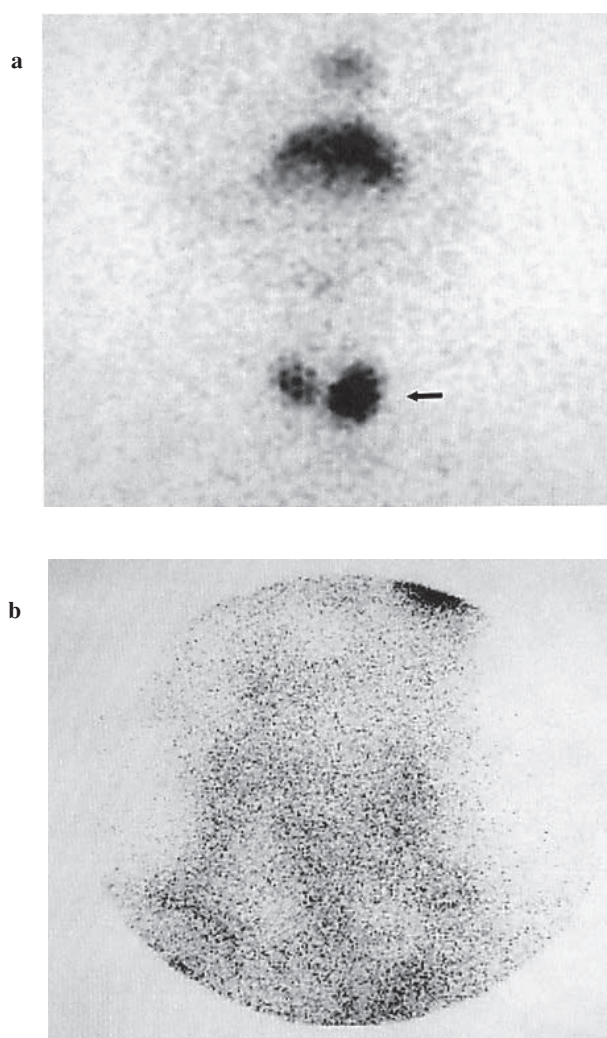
a: Visualization of the remnant thyroid tissue (arrow) on IS in a patient following total thyroidectomy and 3.7 GBq RAI. b: Tc-99m pertechnetate scintigraphy of the same patient. No uptake is seen on spot neck view. This patient's IU was 0.1% with the serum Tg value undetectable (<0.2 ng/ml).
